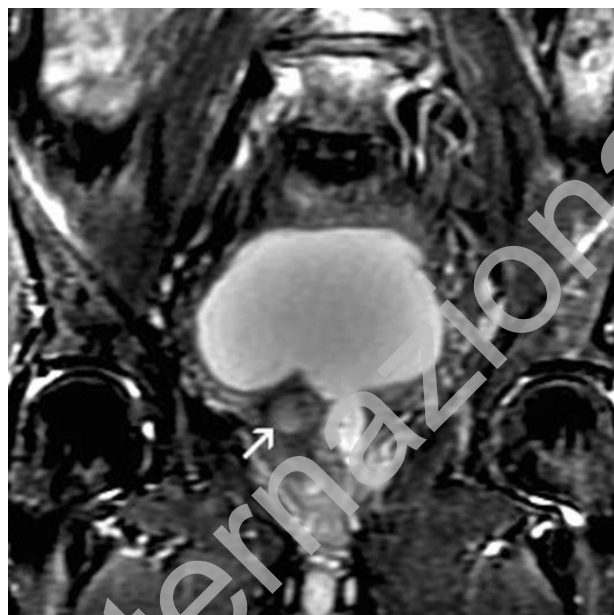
Coronal T2-weighted MR image with fat saturation demonstrates a round lesion of relatively high signal (arrow) at the right side of the transitional zone of the prostate. A TUR cavity is also evident.
